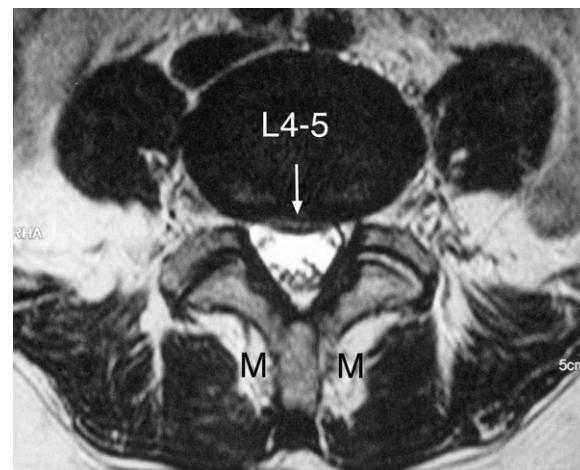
MRI axial T2-weighted image at the L4–5 level showing the shallow focal posterior annular bulge (arrow). M = multifidus muscle with fibro-fatty replacement of part of the muscle.
